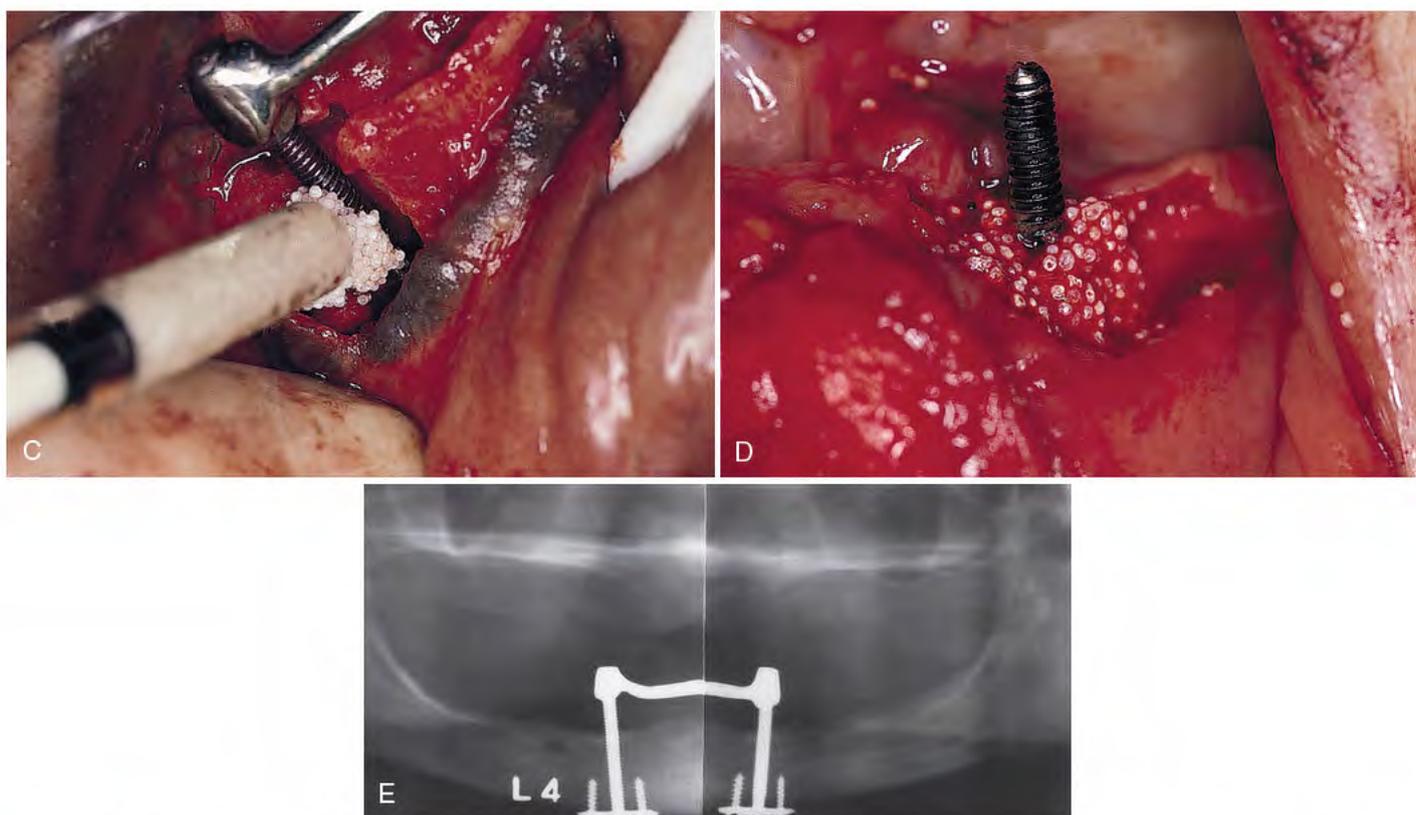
cont'd. C, Hydroxyapatite (HA) in saline is dispensed accurately with a syringe. D, The particles become stabilized by allowing fibrin to serve as a cementing medium. E, The postoperative x-ray film indicates a much-improved support mechanism for these transosteal implants.
